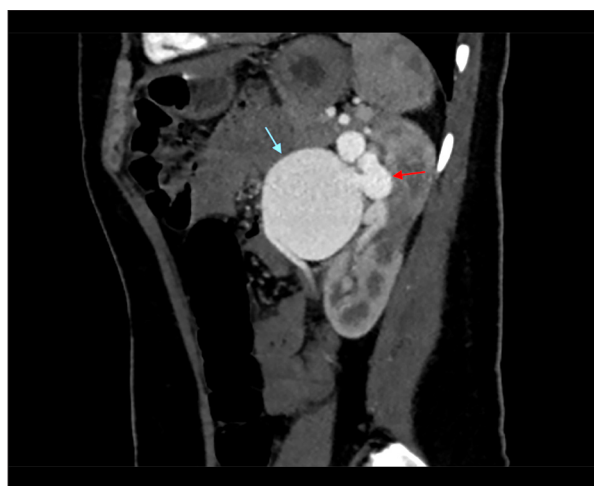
Computed tomography angiogram of the left kidney; sagittal view of abnormal connection between the nidus (red arrow) and the large draining vein (blue arrow).
